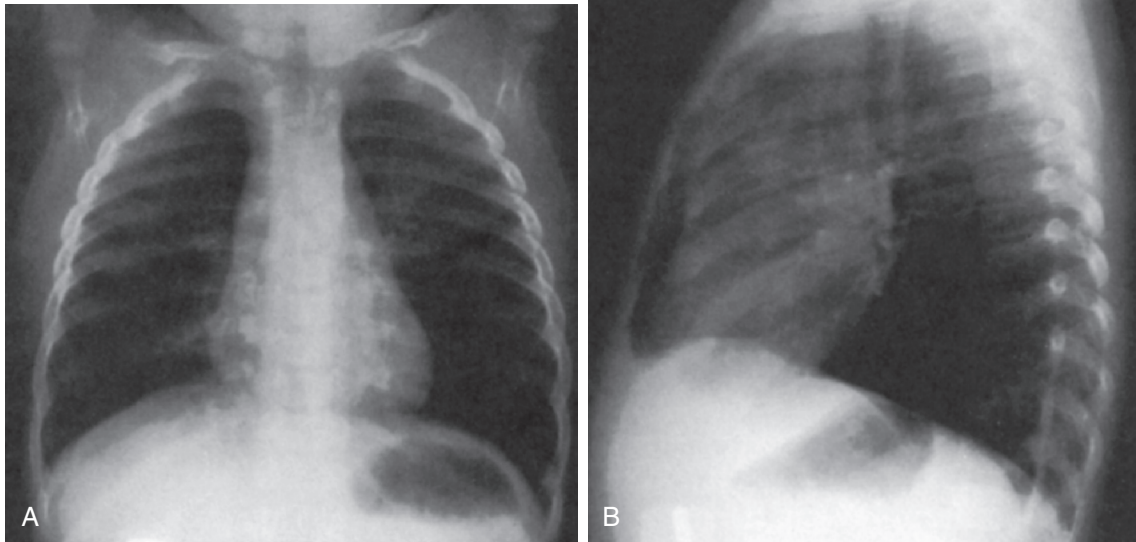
Severe bronchiolitis. Posterior (A) and lateral (B) chest radiographs reveal flattening of the diaphragm and widening of the anteroposterior diameter, which is indicative of severe air trapping. Perihilar markings are accentuated.
